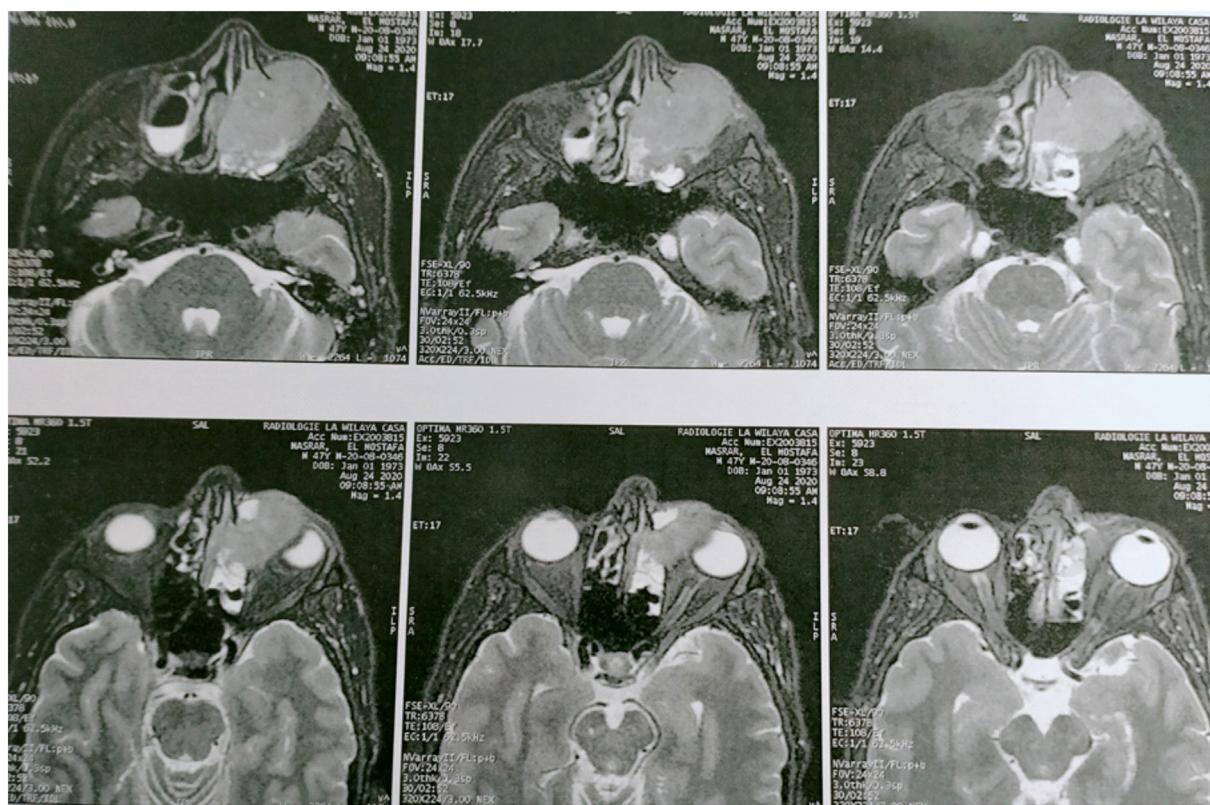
Intra-orbital invasion with infiltration of periorbital fat and ethmoid cells on MRI.
